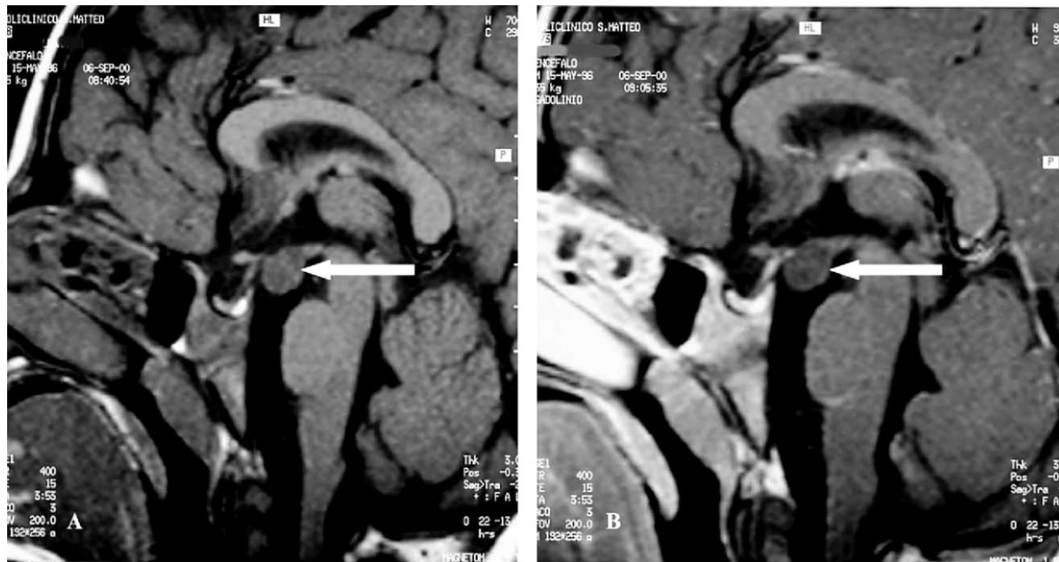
(A) Sagittal T1-weighted image; (B) Gd-enhanced sagittal T1-weighted image. Sessile hamartoma in typical third ventricular location, isointense to gray matter before (A) and after (B) gadolinium administration (*white arrow*).
